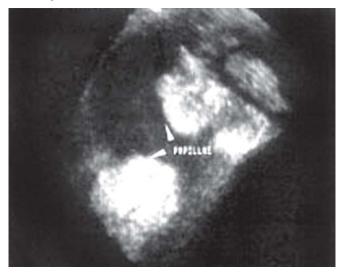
Complex ovarian tumor as seen by three-dimensional ultrasound. Surface view revealed irregular wall proliferations suggestive of ovarian malignancy
